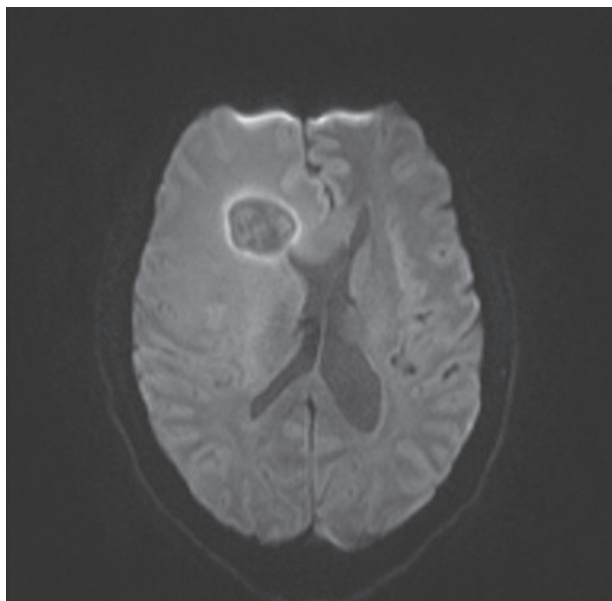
On DWI Sequence, the lesion shows a high diffusion-weighted signal at the periphery while heterogeneous values at the centre.
